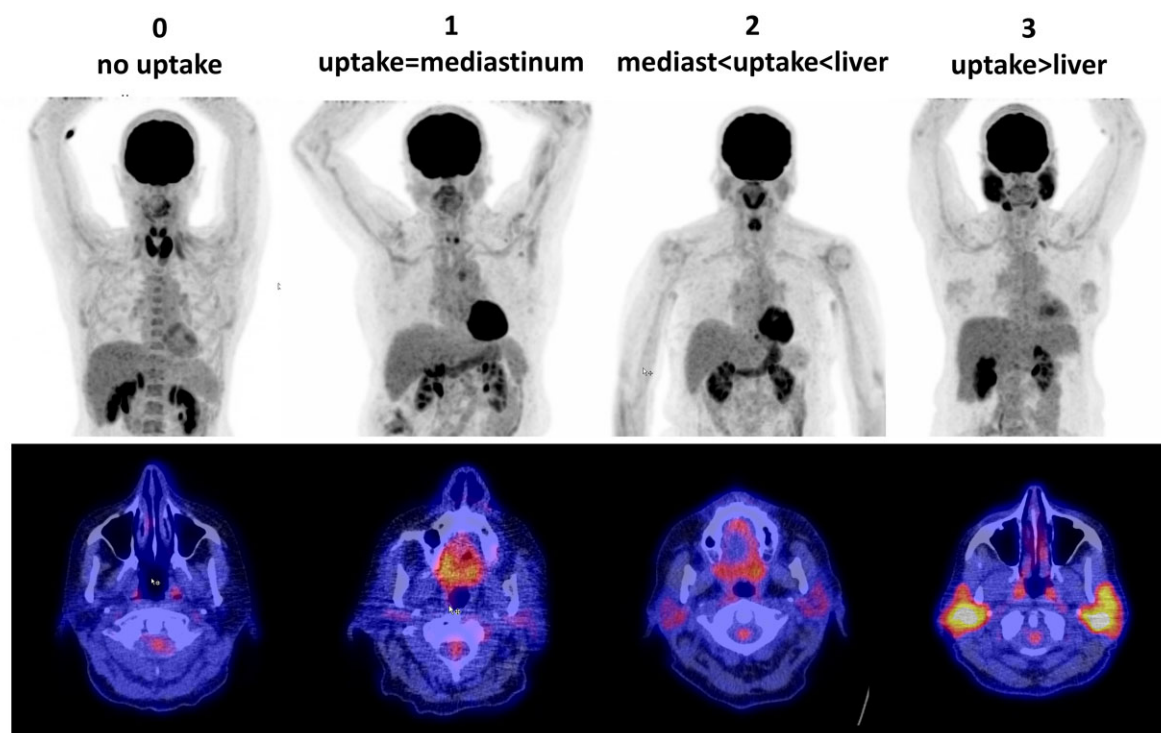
Visual analysis of FDG uptake in parotid salivary glands. Visual analysis based on scoring range 0–3, shown in PET images (upper row) and fused PET/CT-images of the same patients (lower row). Score 0: no FDG uptake in the glands; score 1: FDG uptake in the glands = FDG uptake in mediastinum; score 2: FDG uptake in the glands > FDG uptake in mediastinum, but < FDG uptake in the liver; score 3: FDG uptake in the glands > FDG uptake in the liver. FDG: [^{18}F]-fluorodeoxyglucose
